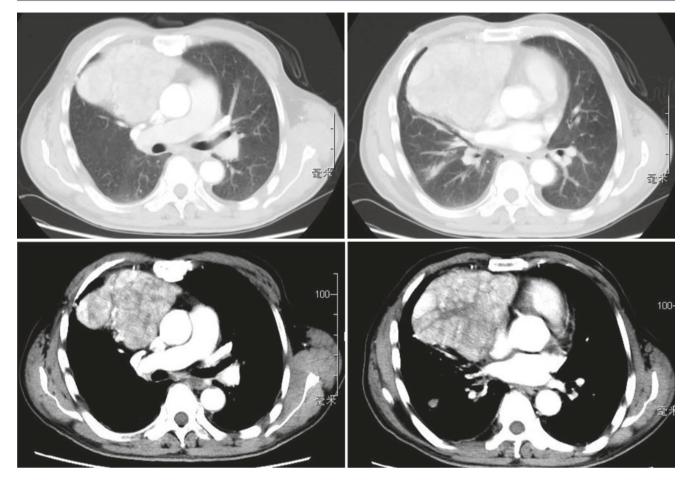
A 40-year-old man with type AB thymoma in the anterior mediastinum. Chest CT showed a mass with multiple nodular enhancement and line-like low-density septa
